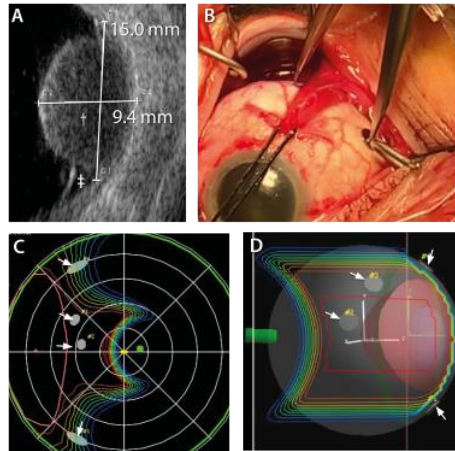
Ophthalmic measurements. (A) Ultrasound measurements of tumor (dagger) prominence and basal diameter. Note the associated retinal detachment (double dagger). (B) Peroperatively, the distance between tumor and marker and distance between markers is measured using a capilar. (C,D) ocular-PT plan with the planned dose distribution. In the fundus view (C), the peroperative and ultrasound measurements are used to define the tumor base, from which a geometric 3D model (D) of the eye including the tumor (red) and markers (arrows) is constructed.
